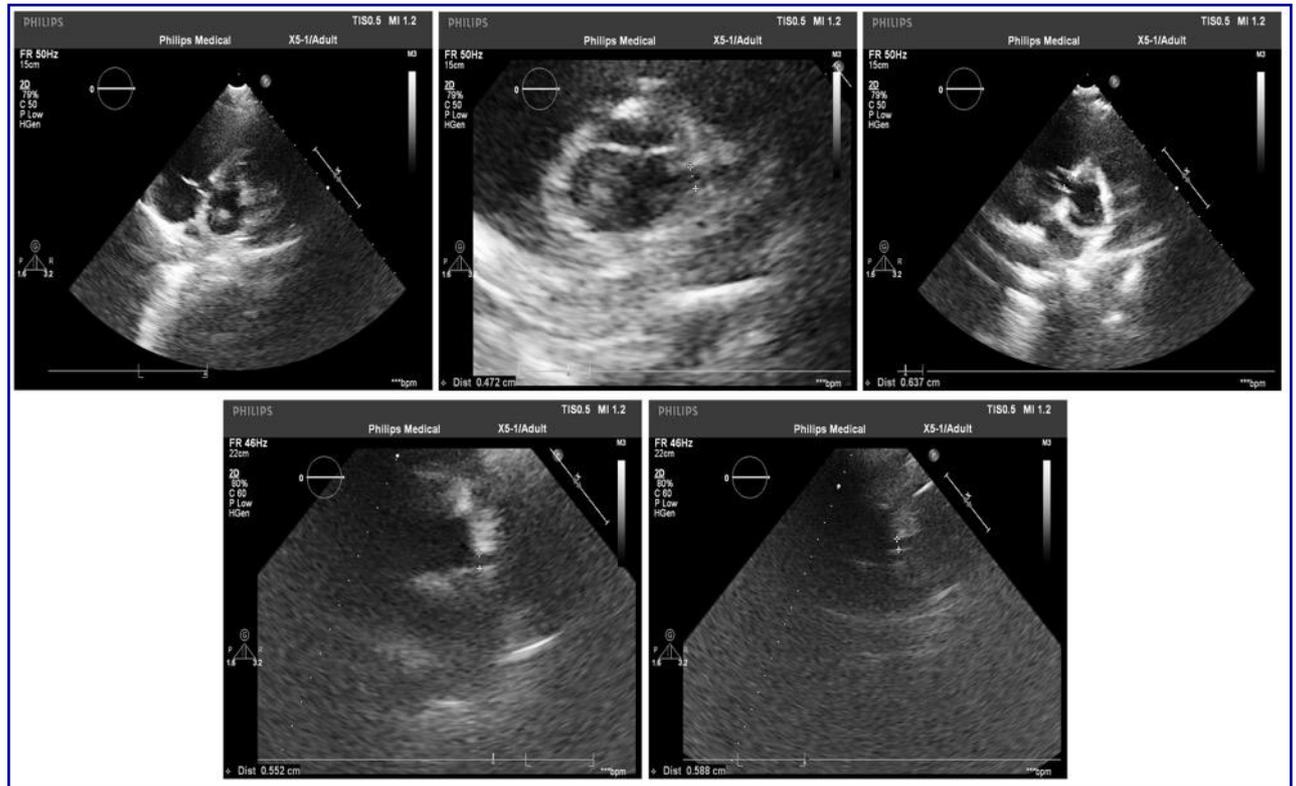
Echocardiography of a patient who underwent PDA closure in the past and the coronaries were dilated.
